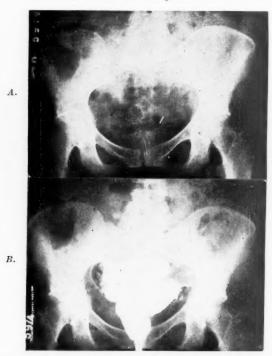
A, Roentgenogram of the pelvis with a metallic foreign body resembling a radon seed opposite the left ischial spine. B, Colon examination showing obstruction to the passage of barium at the junction of the descending and sigmoid areas.
